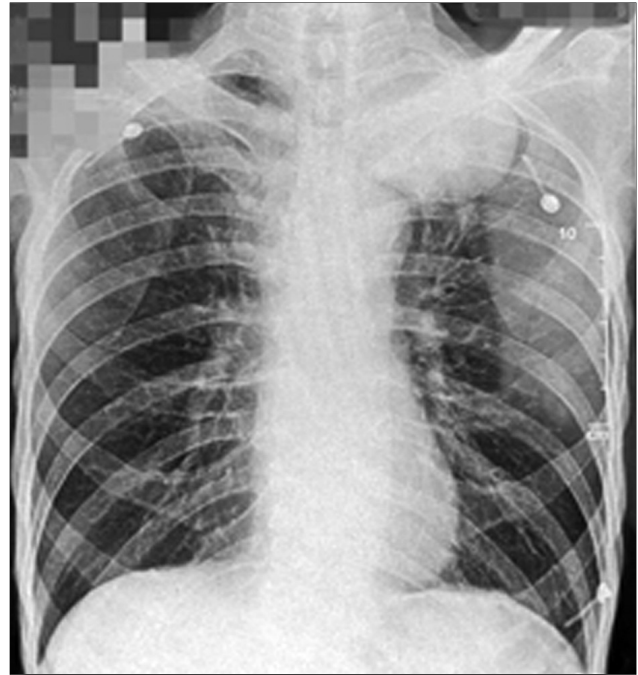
Chest radiography shows left apical lung opacity
